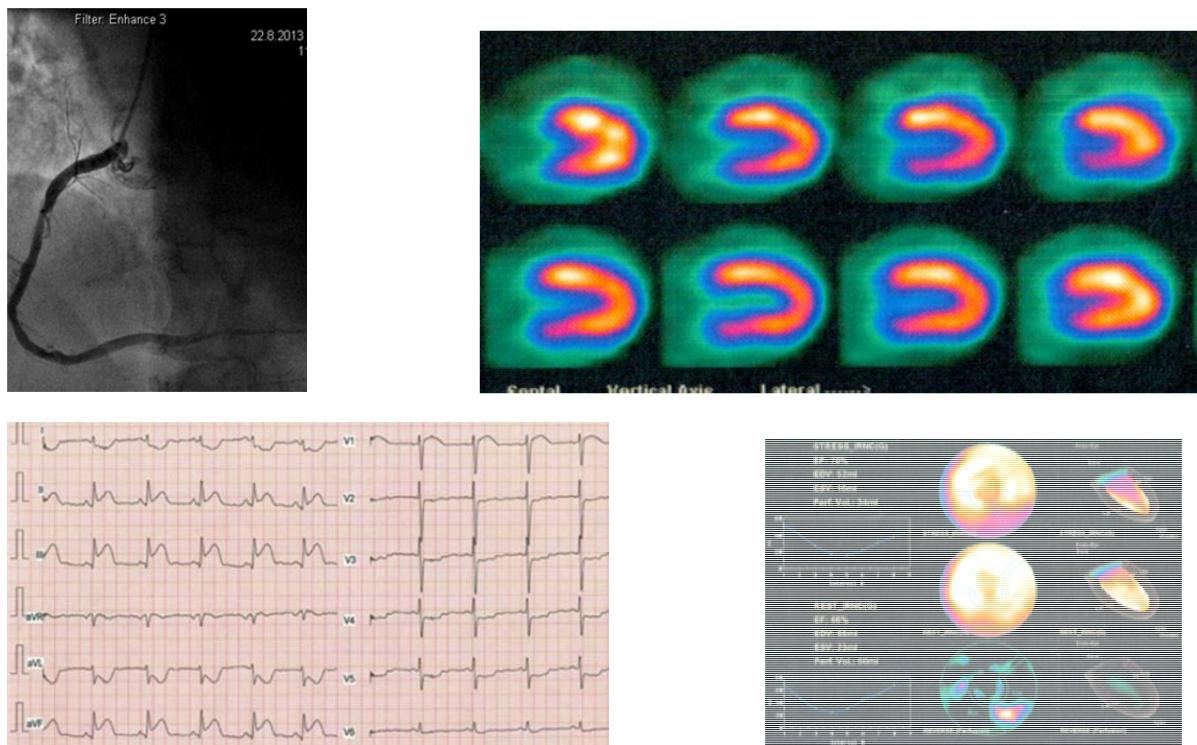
Clinical case 2: 67 y.o female, NSCL of RCA, FFR-0,80 and inferior perfusion defect on stress-rest SPECT, survived STEMI in 14 months after MPI
